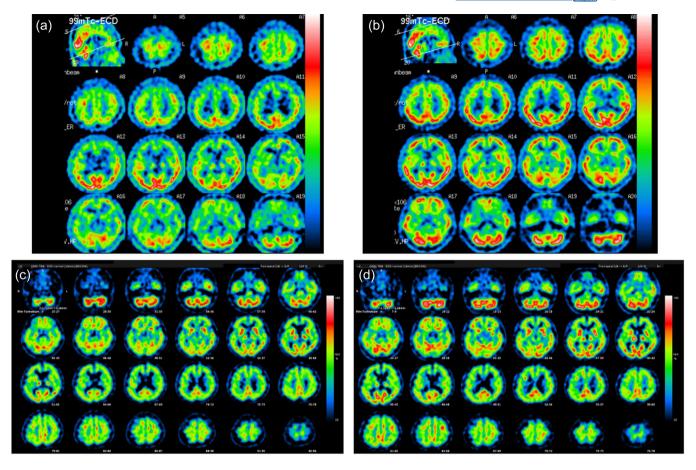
Brain single photon emission computed tomography using technetium-99m-ethyl cysteinate dimer: (a) at the 32nd hyperbaric oxygen (HBO) therapy session, (b) at the 74th HBO therapy session, (c) 8 years after HBO therapy, and (d) 9 years after HBO therapy.
